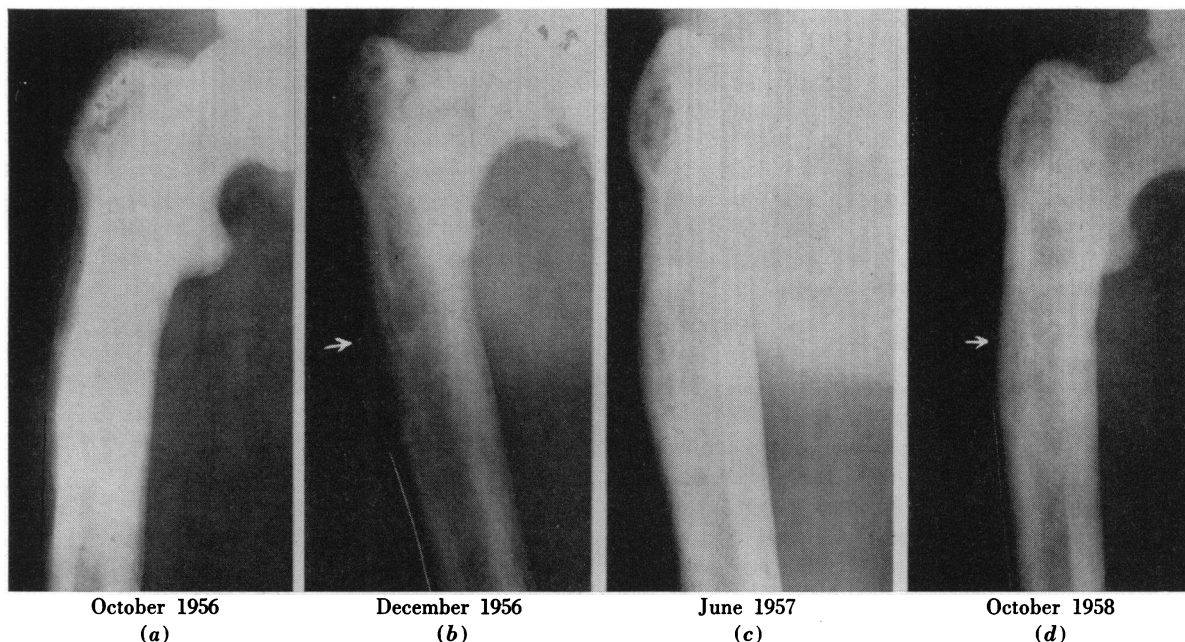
Serial x-ray films showing progression and healing of lesion. Note that the fissure fractures observed in 1956 (arrow) remained stationary. The area of rarefaction along the lateral margin of the femur is marked in for better visualization.
